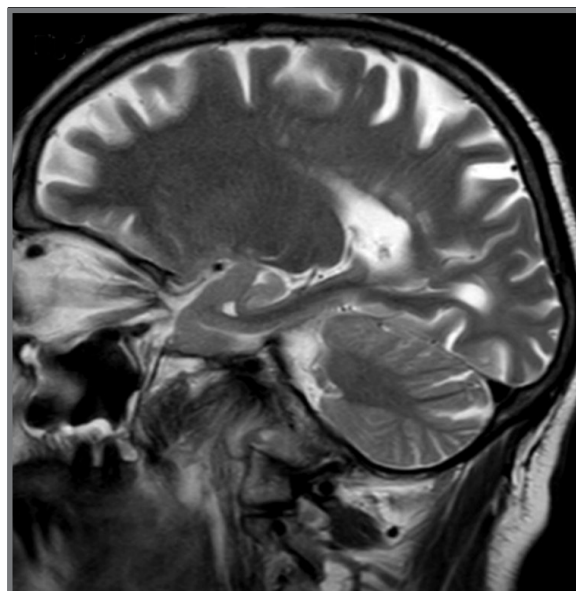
Central or atypical skull base osteomyelitis MR image showing erosion noted in clivus and basi-occiput.
